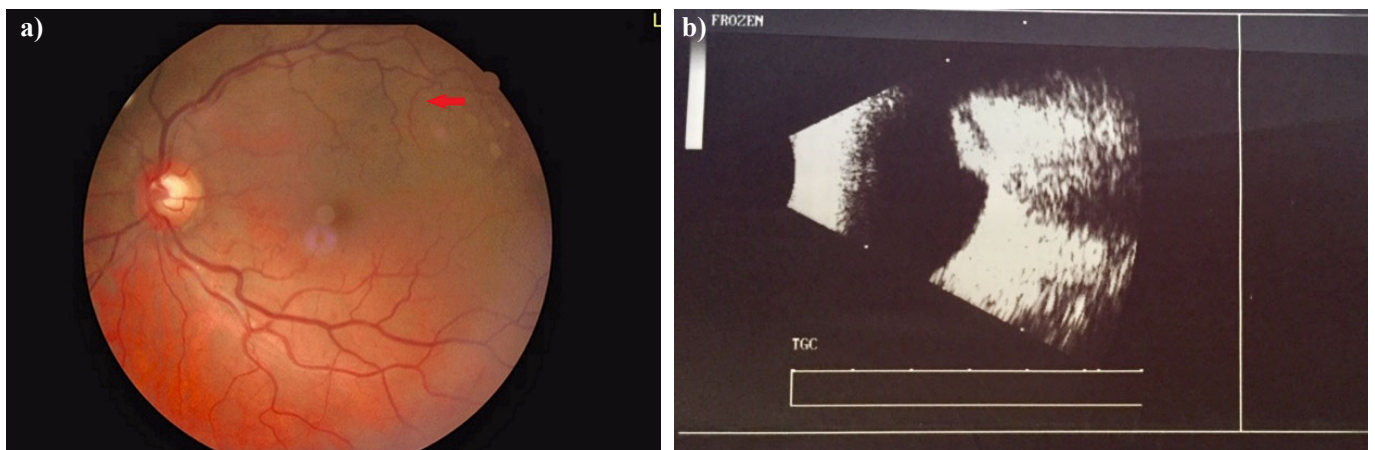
a) Hemorrhagic choroidal detachment (arrow) in the left eye superior to the macula. b) B-scan ultrasonography showing the choroidal detachment.
